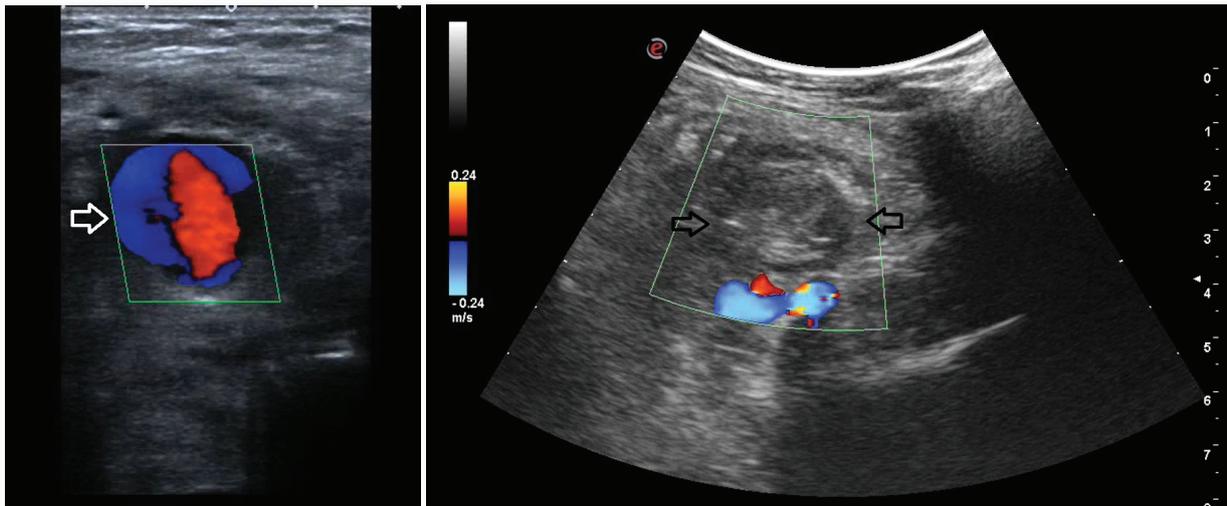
Colour flow Doppler USG imaging showing the existence of a pseudoaneurysm with simultaneous bidirectional flow in its lumen (a) and interruption of the blood flow at the first minute of thromb in injection (b).
